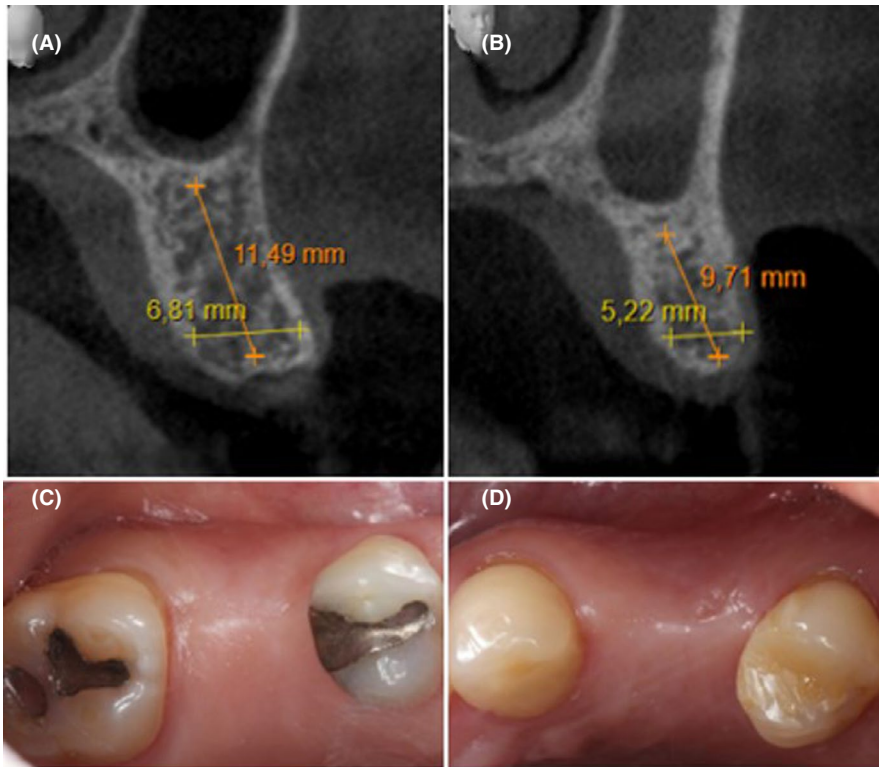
(A–D) Patient 1 pretreatment conditions. CBCTs and occlusal photographs of regions 15 (A and B) and 24 (C and D)
